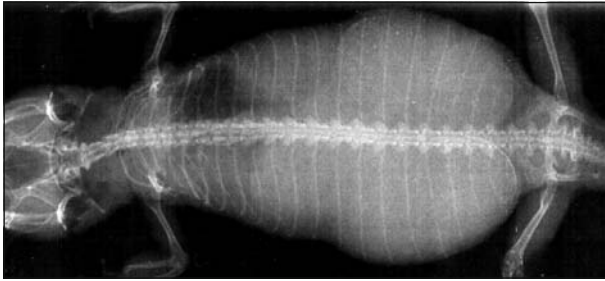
Dorso-ventral radiograph of the leopard gecko showing post-ovulatory dystocia. The eggs are too big in diameter to pass through the pelvis and the caudal pole of each egg is in contact with the other one, making it difficult for one of them to move into the cloacae.
